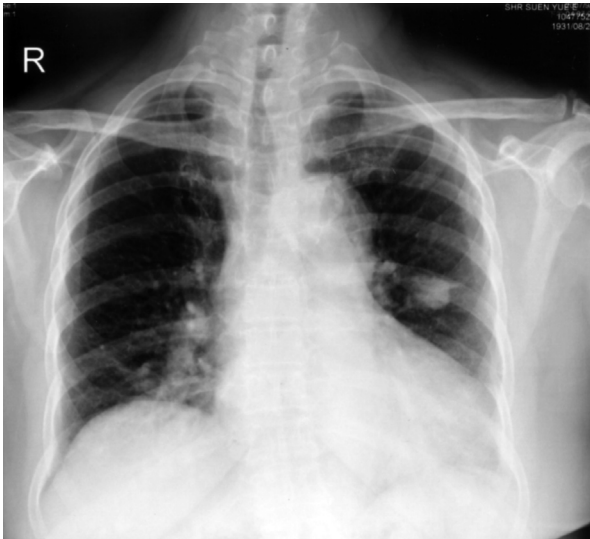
Postero-anterior chest X-ray showing a patchy lesion with relatively clear margin in the left lung.
